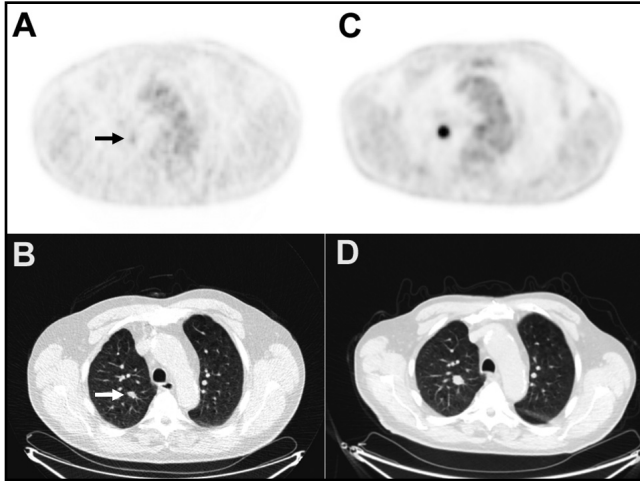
73-year-old man with solitary pulmonary nodule. FDG PET/CT images at baseline (A and B, arrows point to the SPN) and corresponding images after a followup period of 11 months (C and D).
